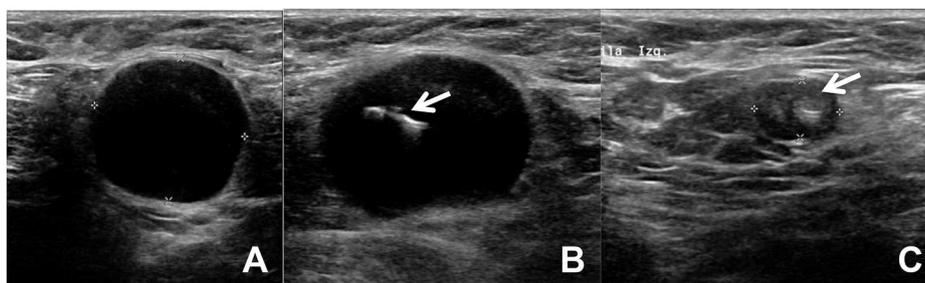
Axillary ultrasound images of another patient included in the study. (A) Enlarged lymph node at diagnosis, with a major diameter of 2.8 cm. (B) Lymph node after colocation of clip (arrow). (C) The same lymph node after NACT, with a partial response and a major diameter of 1.2 cm (arrow).
